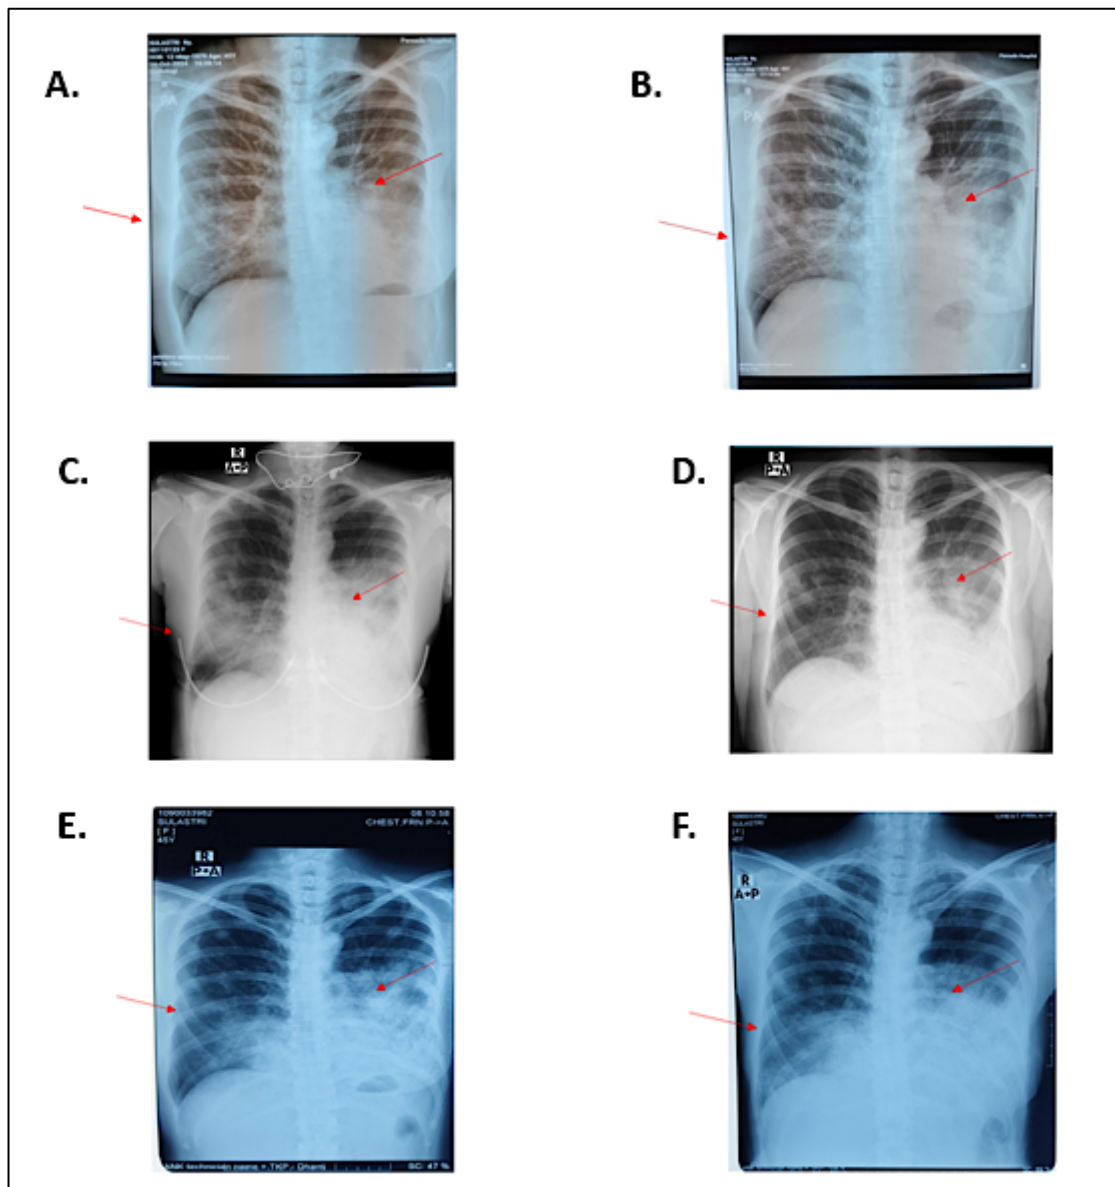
Serial Chest Radiographs Demonstrating Disease Progression from October 2024 to April 2025. (A) Chest radiograph obtained on 4 October 2024 showing findings consistent with infected bronchiectasis, (B) Chest radiograph obtained on 4 November 2024 demonstrating pulmonary edema, left pleural effusion and pneumonia, (C) Chest radiograph obtained on 18 December 2024 showing persistent pulmonary edema, left pleural effusion and pneumonia, (D) Chest radiograph obtained on 24 December 2024 demonstrating persistent pulmonary edema and left pleural effusion with partial improvement of pneumonic infiltrates, (E) Chest radiograph obtained on 6 April 2025 showing bilateral paracardiac consolidations, multiple pulmonary nodules and left pleural effusion, (F) Chest radiograph obtained on 9 April 2025 demonstrating persistent pulmonary abnormalities compared with the previous examination
